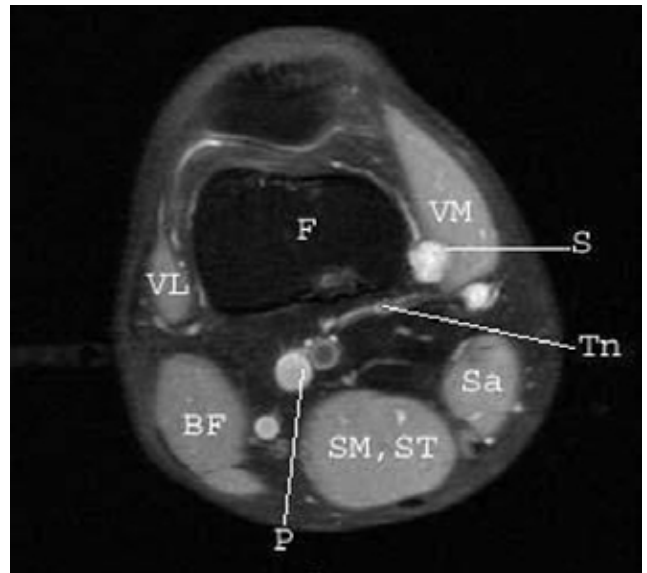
Axial T<sub>2</sub>-weighted MRI from earlier presentation showing 2 of the larger lesions located in the posterior medial deep fascia. Abbreviations: BF, biceps femoris; F, femur; MRI, magnetic resonance image; P, popliteal artery and vein; S, schwannoma; Sa, sartorius; SM, semimembranosus; ST, semitendinosus; SV, saphenous vein; Tn, articular branch tibial nerve; VL, vastus lateralis; VM, vastus medialis.
